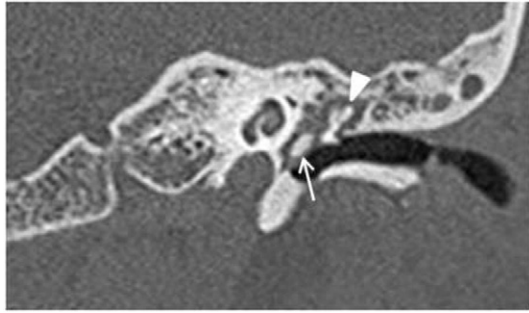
Coronal CT image of left temporal bone shows the abnormal dense bone formation separate from the ossicles (arrowhead) and promontory. Abnormal soft tissue within the middle ear with bone formation is demonstrated (arrow).
